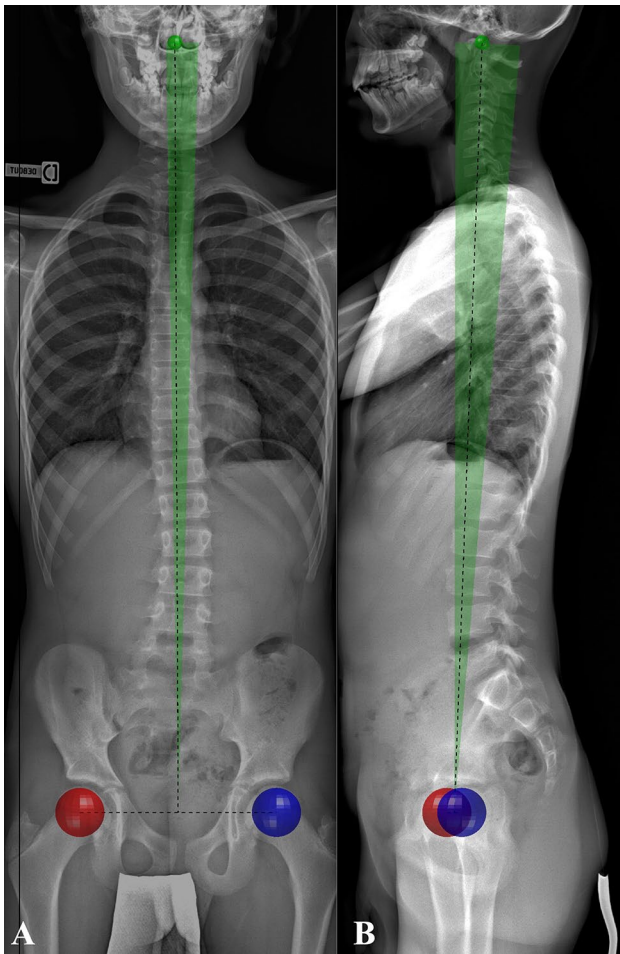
Characterization of the OD-HA measurement and its reference corridor. The centre of the femoral heads is represented by the red circle on the right side and the blue circle on the left (HA). The most superior point of dentiform apophyse of C2 is represented by the green circle (OD). The black dotted line represents the measurement of the OD-HA on the frontal (a) and lateral (b) radiographs. The green zone delimits the reference corridor between the 5th and 95th percentiles of non-scoliotic patients
